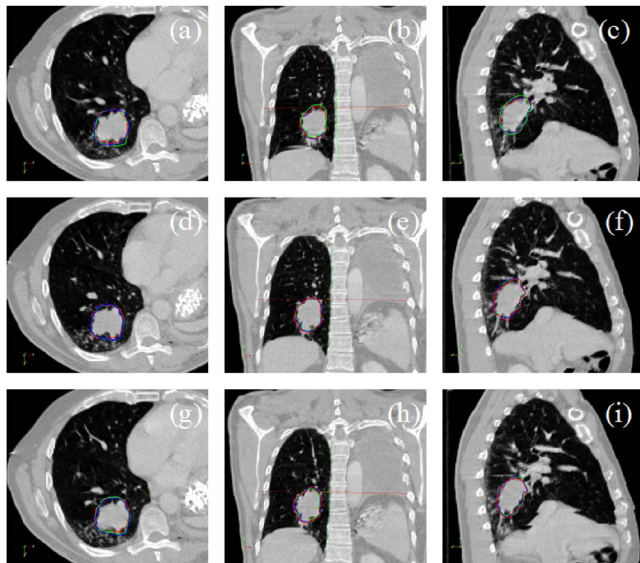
Axial, coronal, and sagittal views of CT images along with GTV contours for the third patient. Top row: phase 2; middle row: phase 4; bottom row: phase 7. Rigidly mapped and target contours are displayed. Template contour is also overlaid on displayed phases.
